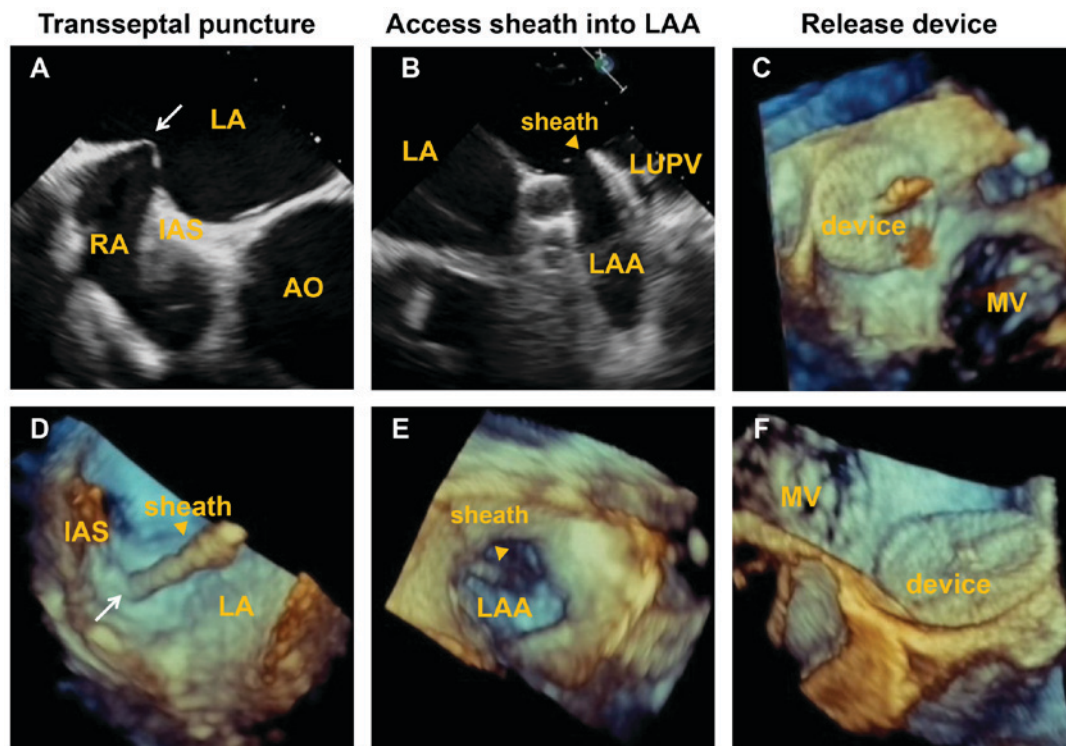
LAA closure procedures under the guidance of (A and B) two dimensional TEE and (C-F) real time-three dimensional TEE. (A and D) Representative images of interatrial septal puncture (arrow). (B and E) Representative images of the access of sheath into LAA. (C and F) Representative images of release of device. TEE, transesophageal echocardiography; AO, aorta; IAS, interatrial septum; LA, left atrium; LAA, left atrial appendage; MV, mitral valve; RA, right atrium.
